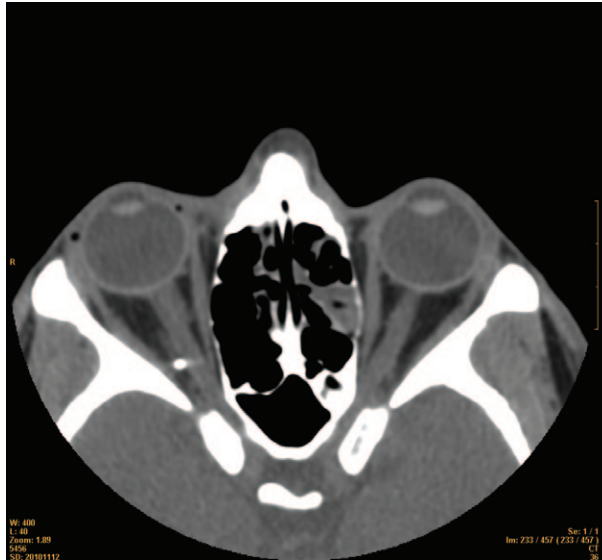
CT scan showing metallic foreign body adjacent to right optic nerve.
